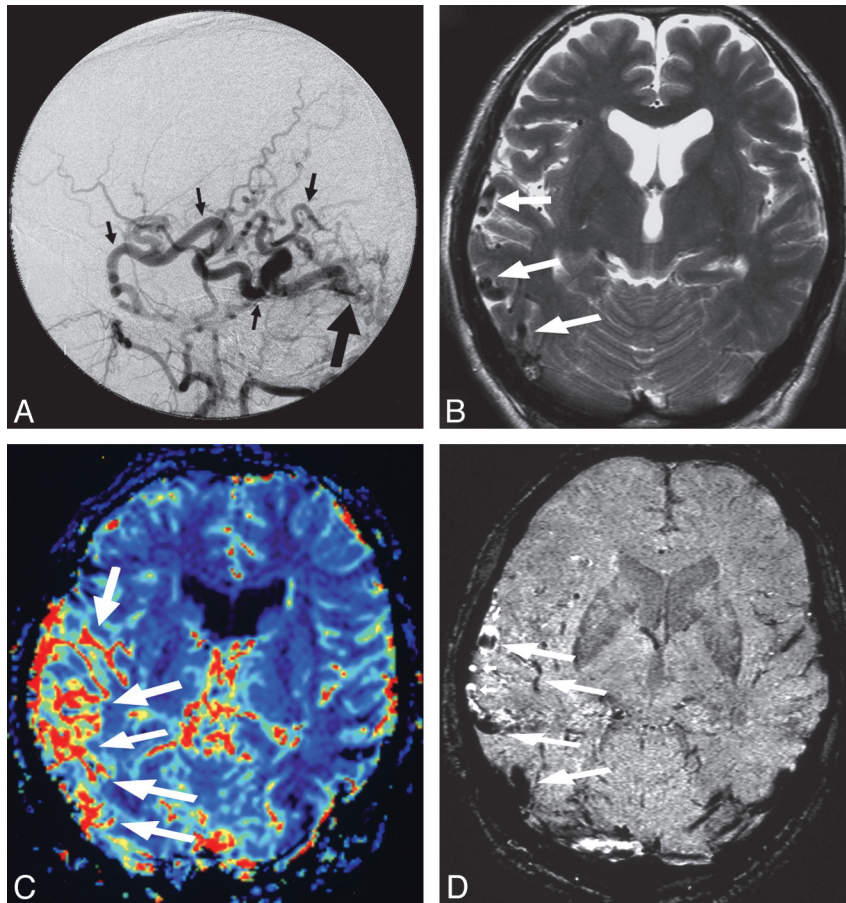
DAVF at the right TSS with a right affected hemisphere in a 55-year-old man (case 10). *A*, Arterial phase of a right external carotid angiogram shows a DAVF (large arrow) with venous drainage directly into the right vein of Labbé (Cognard classification type III) (arrows). *B*, T2-weighted image shows abnormal flow voids in the right temporo-occipital region (arrows). *C*, DSC shows increased cerebral blood volume in the right temporo-occipital region (arrows). *D*, SWI depicts dilated cerebral veins as hyperintense vessels (small arrows), though most dilated cortical veins are seen as typical hypointense vessels (large arrows).
